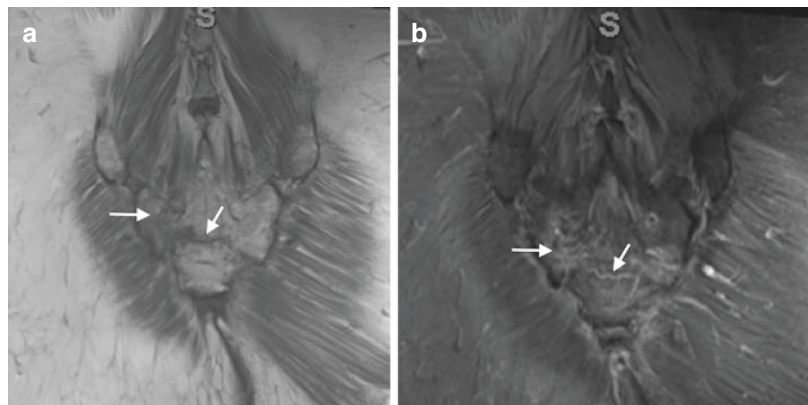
MRI including sagittal (a) T1 and (b) T2 series demonstrating right vertical SIF with horizontal component
